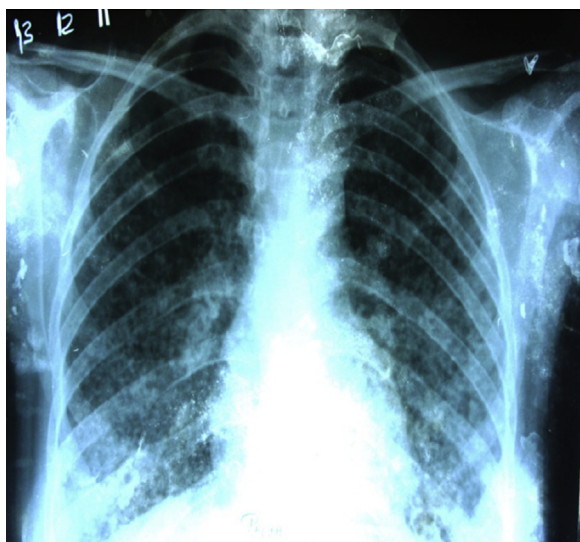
Chest X-ray showing bilateral reticulo-nodular shadows.
